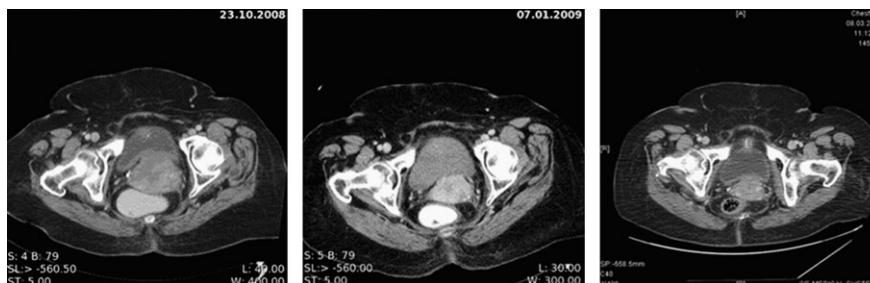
Repeated computed tomography scan conducted at the initiation of imatinib therapy ($14 \times 9 \text{ cm}^2$), 4 and 6 months thereafter, respectively, demonstrating the substantial regression of the endometroid uterine sarcoma ($4 \times 3 \text{ cm}^2$).
